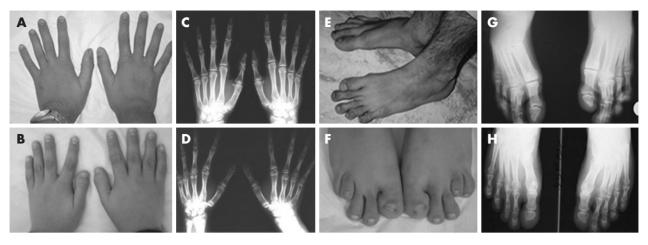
Intrafamilial phenotypic variability in Larsen syndrome. Clinical and radiographic images of hands and feet from different members of family 5. Variation in the degree of hypoplasia of the distal phalanx of the thumb (compare A and C with B and D). (A,C) IV20, (B,D,F) IV21, (E,G) IVI, (H) III3. Informed consent was obtained from all patients/guardians for publication of this figure.
